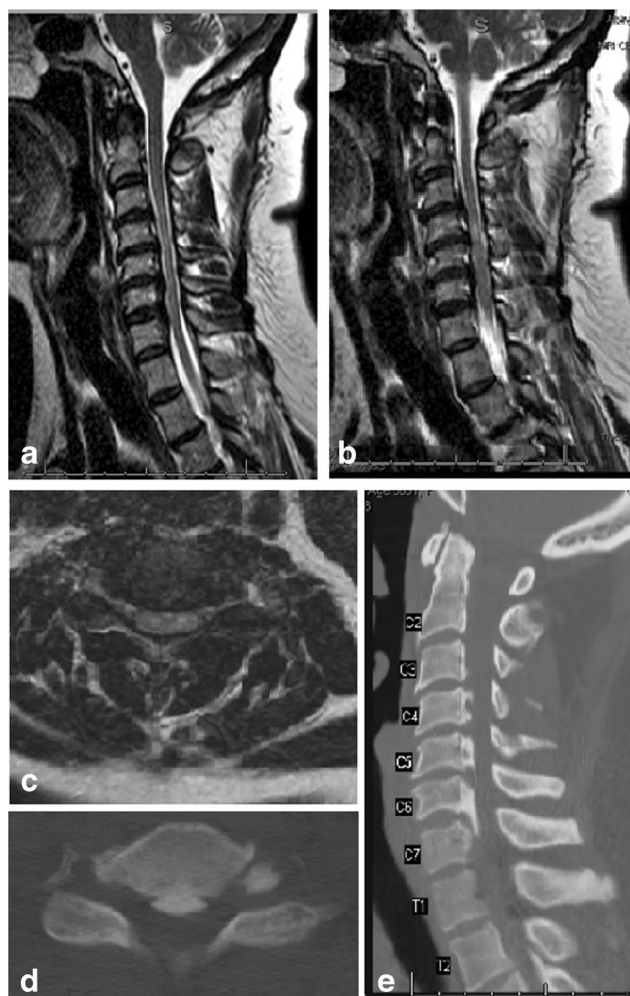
A 65-year old male presented to clinic with myelopathy. Selected sagittal (a, b) and axial (c) demonstrated cord compression at C2/3, C5/6, and C6/7. Due to retrovertebral cord compression from hypointense masses on T2 imaging, a CT was obtained to evaluate for OPLL. Selected sagittal (d) and axial (e) cuts demonstrate OPLL at the sites of cord compression. A C2–C7 posterior cervical decompression and C2–T1 instrumented fusion was performed (f)
